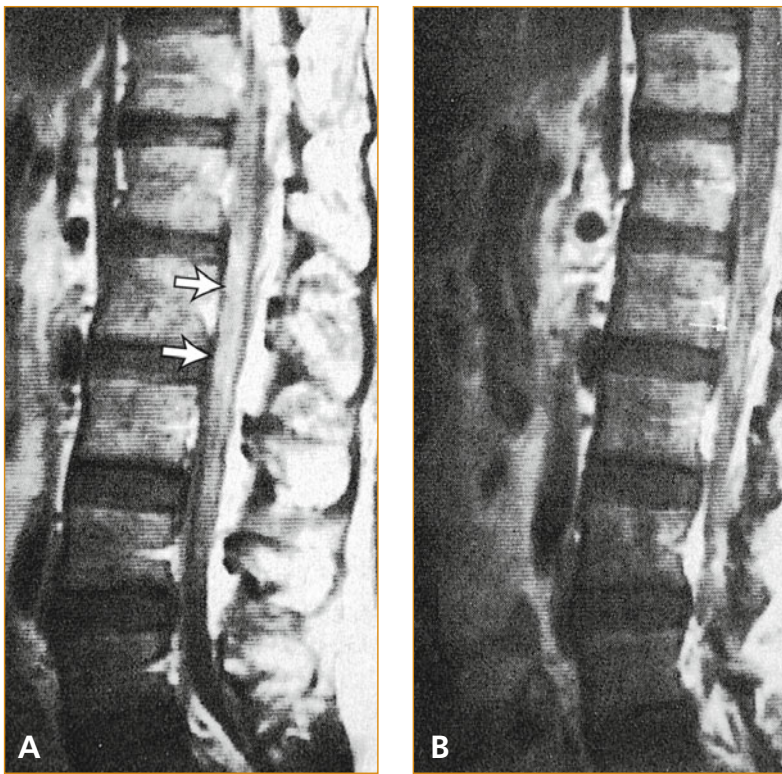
Enhanced T1-weighted sagittal magnetic resonance image of nerve roots from L1 to L4 and the cauda equina region (arrows) in a patient with cytomegalovirus polyradiculitis/polyradiculomyelitis (A). In the right half of the picture, the pial lining of the sac is also enhanced. Usually these lesions are visible only with enhancement (B). (From Talpes *et al.* [57]; with permission.)
